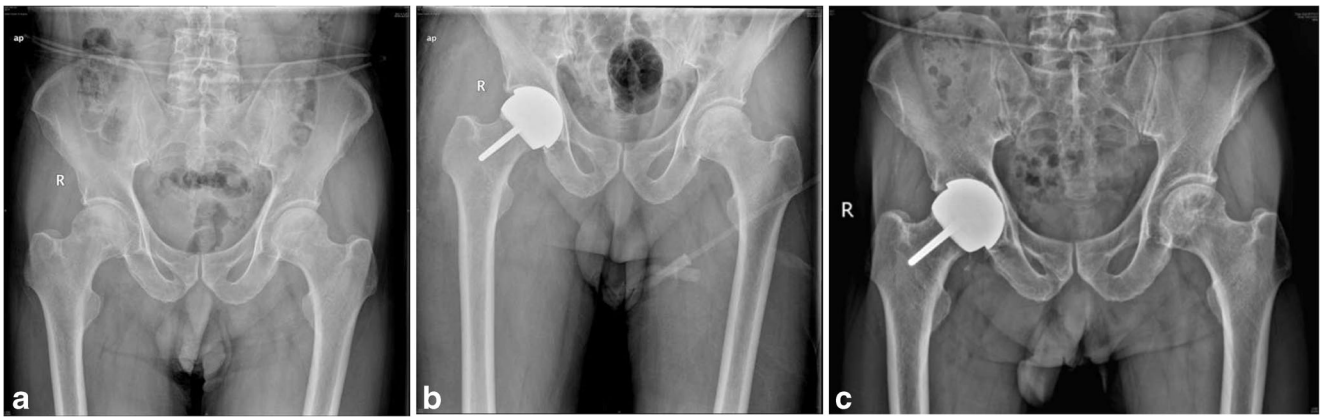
A 65-year-old gentleman with bilateral femoral head necrosis underwent HRA on the right side in 2008. Pelvic radiographs: a preoperation, b 5 days post operation, c 9 years post operation. Notice that the left femoral head did not collapse over time
